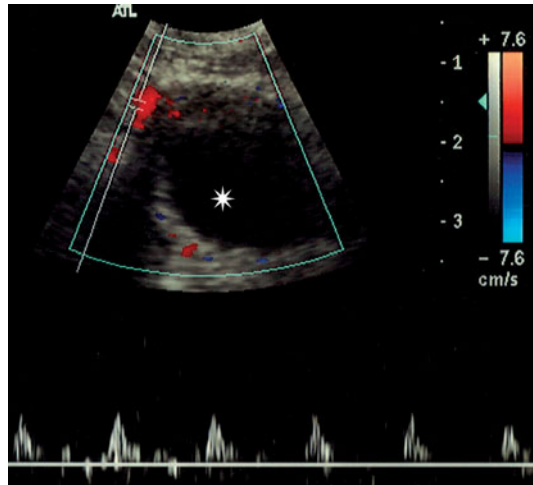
Transvaginal ultrasonography. Flow pattern trace of the right ovarian artery of a woman of fertile age. The *asterisk* indicates a follicle in the preovulatory phase
